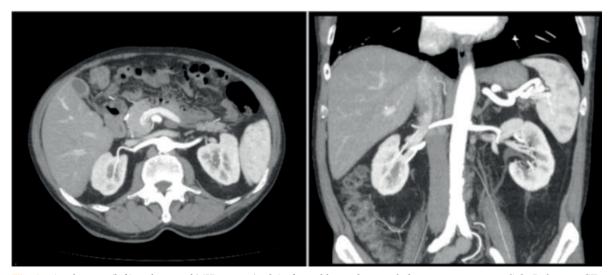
Axial image (left) and coronal MIP image (right) of an additional arterial phase acquisition in a Split Bolus uro-CT, in which the abdominal aorta to both renal arteries to the hilar regions of the kidneys are visible.*
